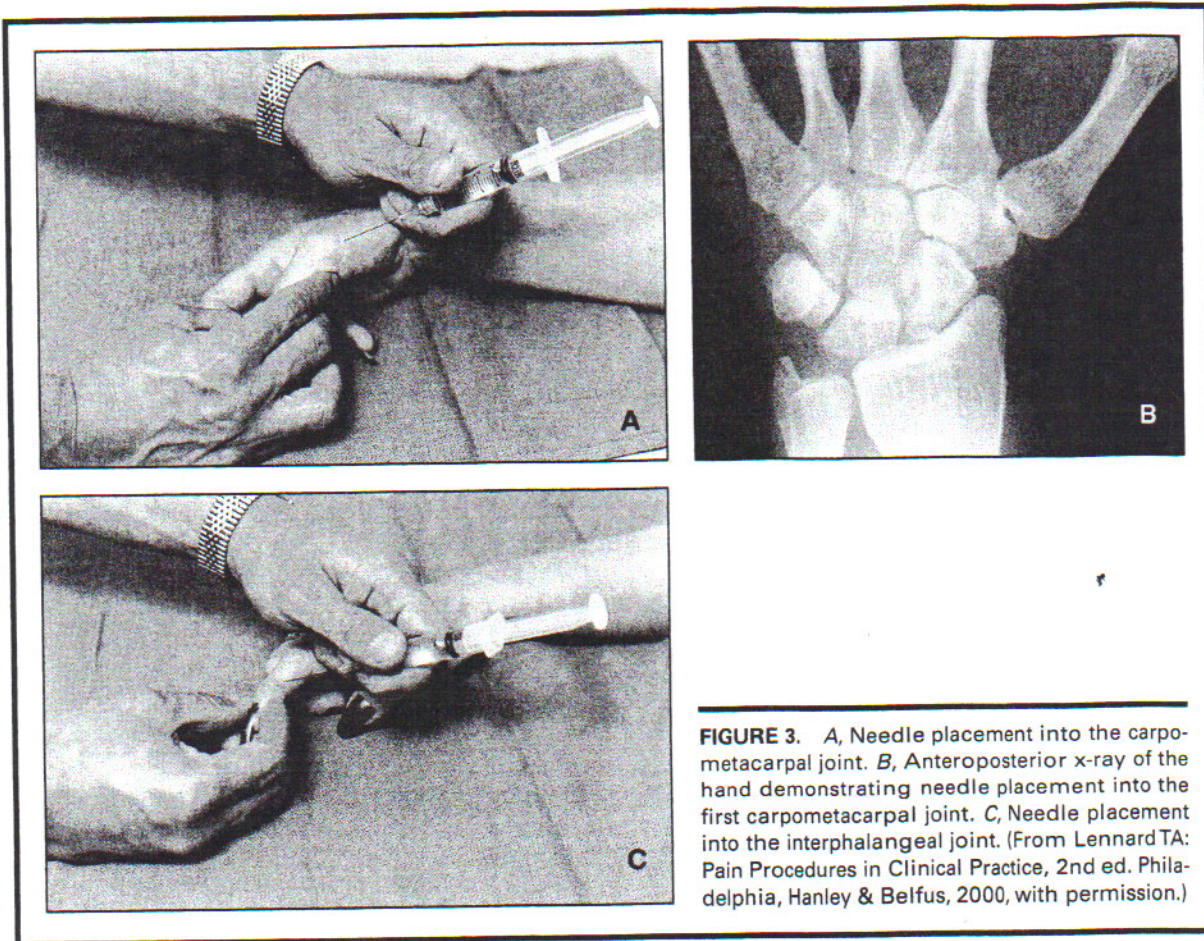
A, Needle placement into the carpo-metacarpal joint. B, Anteroposterior x-ray of the hand demonstrating needle placement into the first carpo-metacarpal joint. C, Needle placement into the interphalangeal joint. (From Lennard TA: Pain Procedures in Clinical Practice, 2nd ed. Philadelphia, Hanley & Belfus, 2000, with permission.)
